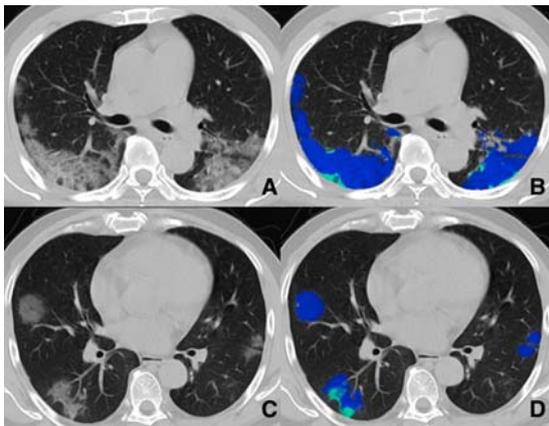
CT images of patients without (A/C) and with annotations (B/D) showing the utility of AI/ML software. The areas of GGO are marked in blue on the annotated images and consolidation as green. Quantification of lung involvement is also possible. Images courtesy of Predible Health.
